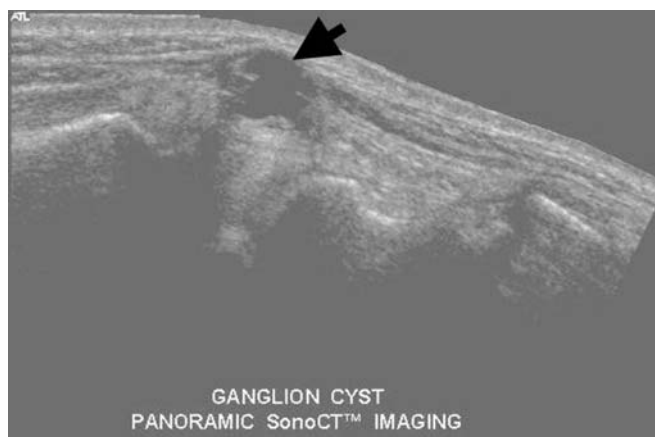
Panoramic sagittal compound ultrasound of the wrist showing a ganglion cyst (arrow).
